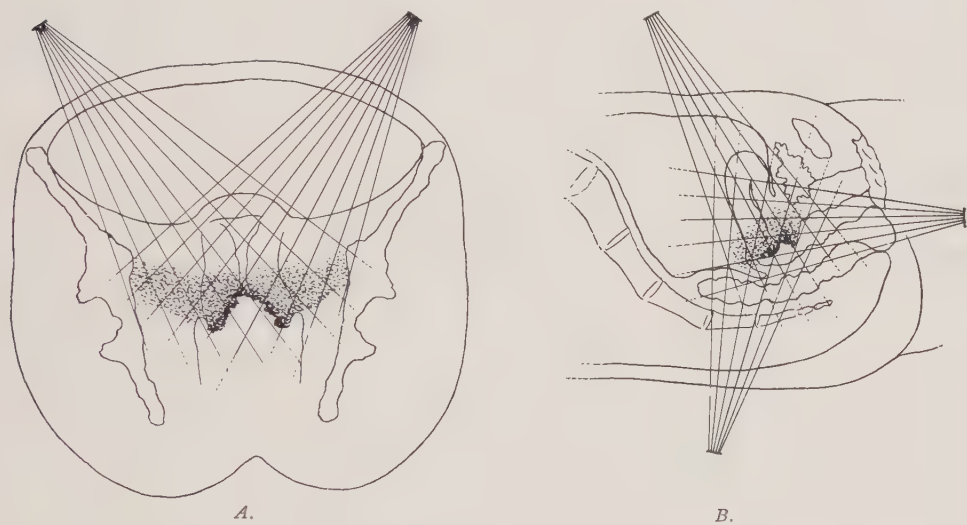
X-ray treatment of carcinoma of cervix uteri. In order to place sufficient dosage in the cancer area without injury to the overlying skin, extensive cross firing is necessary, and the use of many ports of entry one after another. *A*, indicates successive steps in firing through lateral portions of the abdomen. *B*, indicates other ports of entry—the central abdomen, the sacral region and the pelvic outlet. Improvements in technic have now made practical x-ray treatment through a vaginal speculum.
